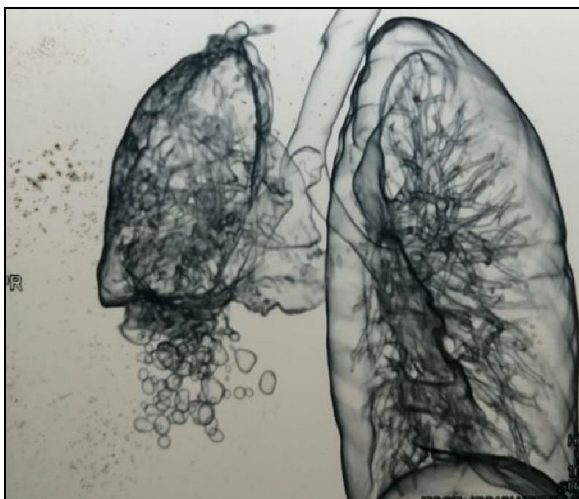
3D CT scan chest - preoperative
